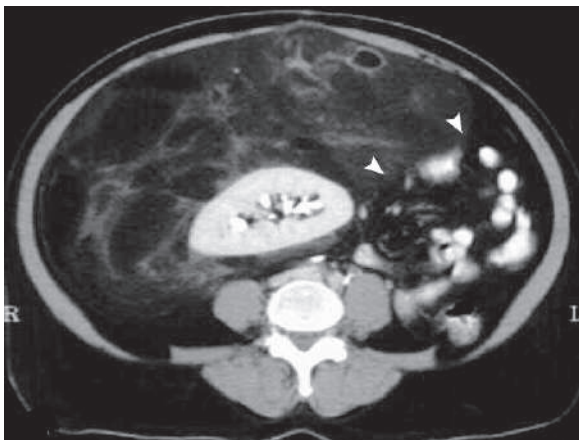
Axial abdominal postcontrast CT shows severe abdominal fatty proliferation that pushes the left kidney and the intestines to the left abdominal cavity region (arrowhead) due to proliferating retroperitoneal liposarcoma
